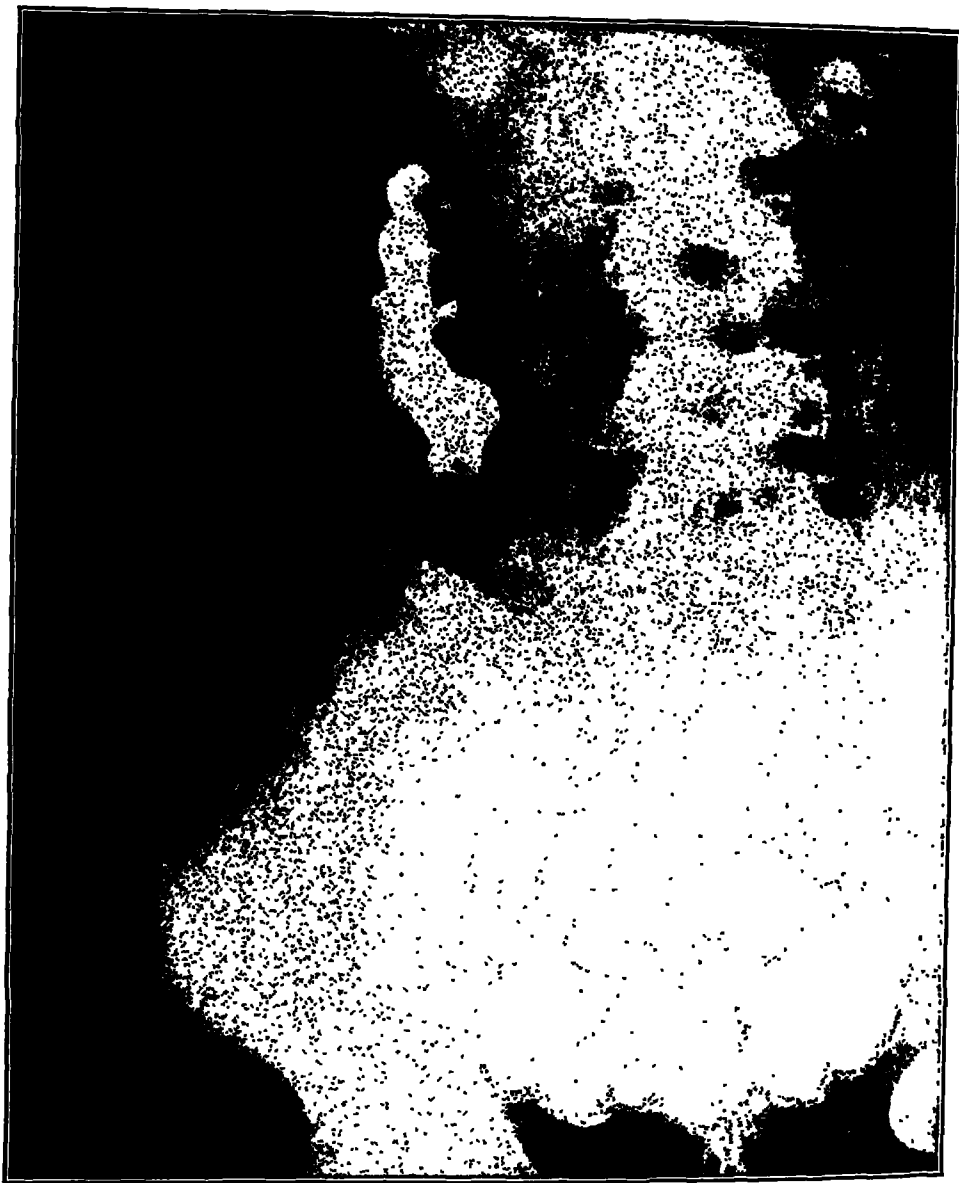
(case 6).—Roentgenogram, Dec. 7, 1927, made eight hours after ingestion of barium, showing marked ileal stasis. The head of the barium column has reached the descending portion and sigmoid.
